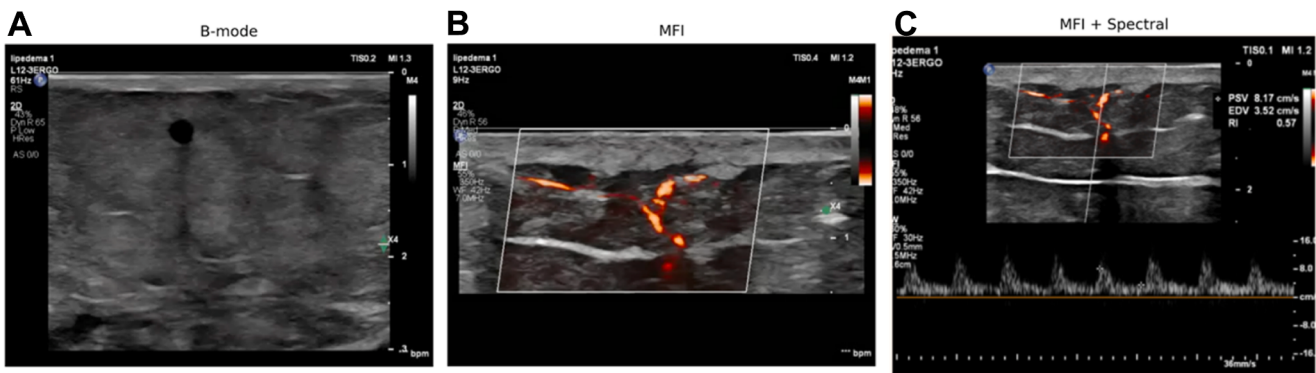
Ultrasound assessment of subcutaneous tissue in lipedema. (A) B-mode image demonstrating diffuse subcutaneous thickening and loss of architectural organization in the hypodermis. (B) Microflow imaging (MFI) showing discrete perinodular microvascular flow not visible with conventional color Doppler. (C) MFI combined with spectral Doppler demonstrating a low-resistance arterial flow pattern (resistance index [RI] 0.57), consistent with inflammatory hypervascularization.
